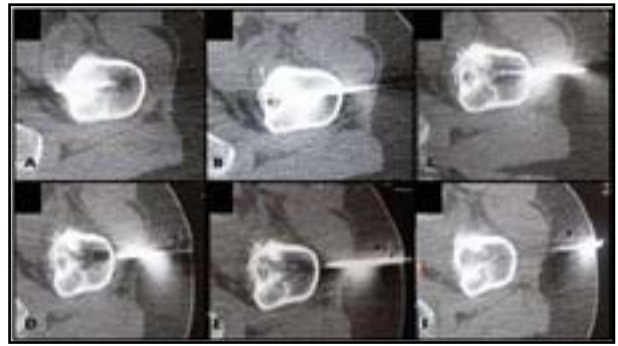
The Kirschner wire was guided under CT guidance to the targeted nidus in femur from the lateral to the medial thigh.
